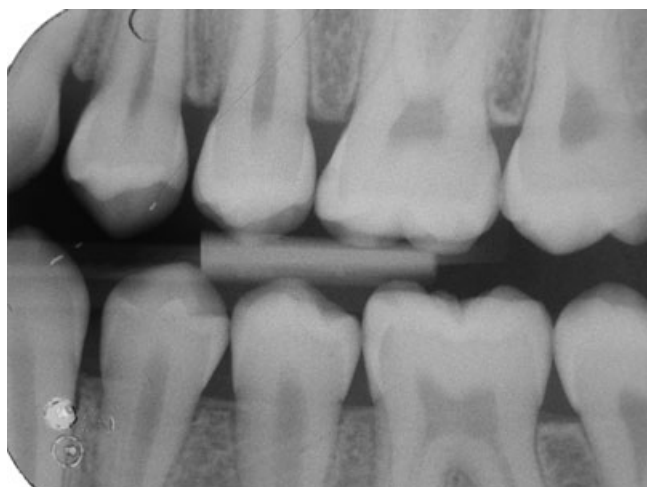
Radiograph showing bitewing 1.
